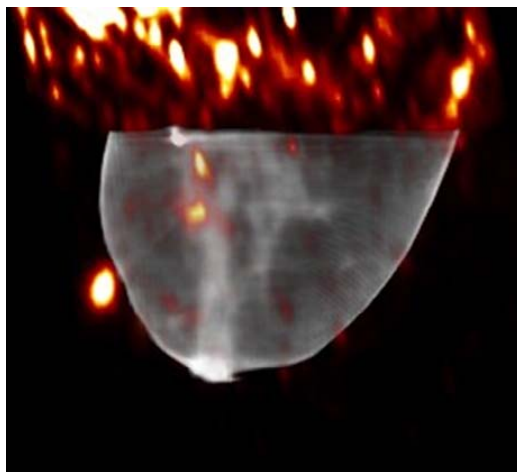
Fused SPECT-CT image. SPECT image is displayed in the “hot” scale, (red, orange and yellow) while the CT image is displayed in the gray scale. The CT boundary is used to delineate the volume of interest for SPECT quantification. The average activity value in the SPECT image is 0.04 $\mu\text{Ci/mL}$, within the documented normal range (0.03-0.07 $\mu\text{Ci/mL}$).
